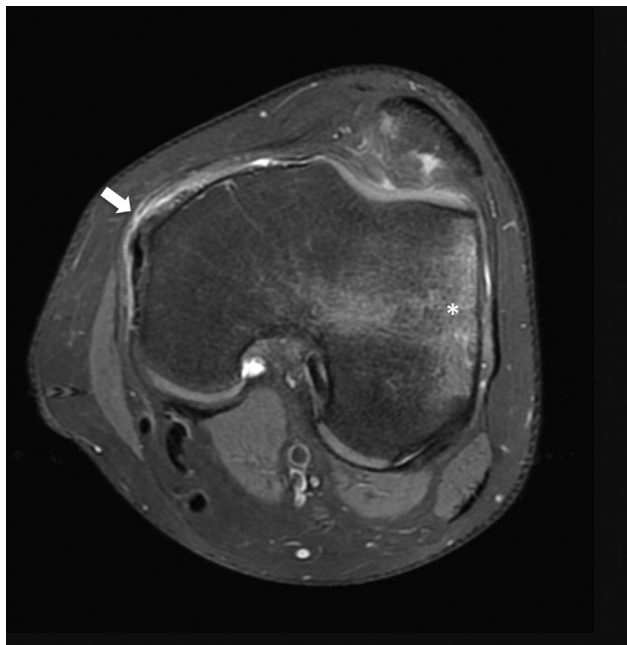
Axial PD fat sat (A) and T2-weighted (B) views showing a partial injury to the MPFL, with bony avulsion of its patellar attachment (white arrow), a subchondral impaction fracture of the inferomedial patella (curved arrow), and a bone edema at the lateral femoral condyle (asterisk).
